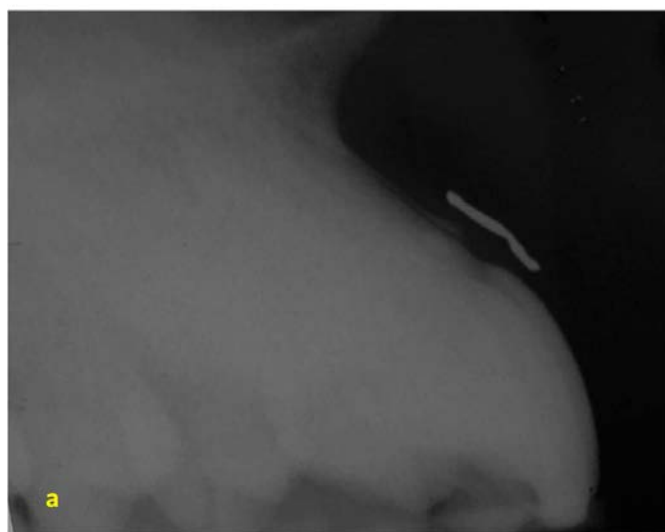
3(a) radiographic view of index tooth with lead plate. 3(b) radiographic measurement points for assessment of gingival thickness and alveolar bone thickness's value.
